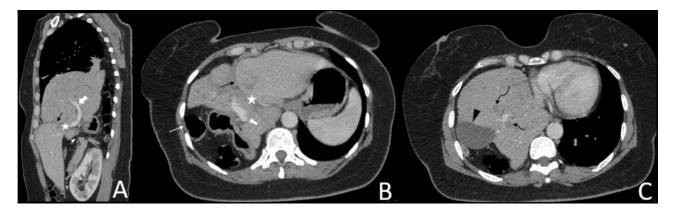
CT thorax and abdomen. (A, B) Sagittal and axial views show a patent left portal vein above the diaphragm in the right chest cavity (white fat arrow), and an interruption of the right hemidiaphragm (black arrow). The diaphragmatic defect is also visible in the sagittal view in A (white arrowhead). (C) axial slices, located just above those in figure B, display a large hepatic hernia within the right hemithorax, displacing the heart to the left, with an abnormally rotated gallbladder (black arrowhead). Moderate biliary dilatation is primarily noted in the herniated left liver lobe (wavy arrows, C). Additionally, the collar sign (white star, A and B) and dependent viscera sign (white arrow, B) are clearly visible.
